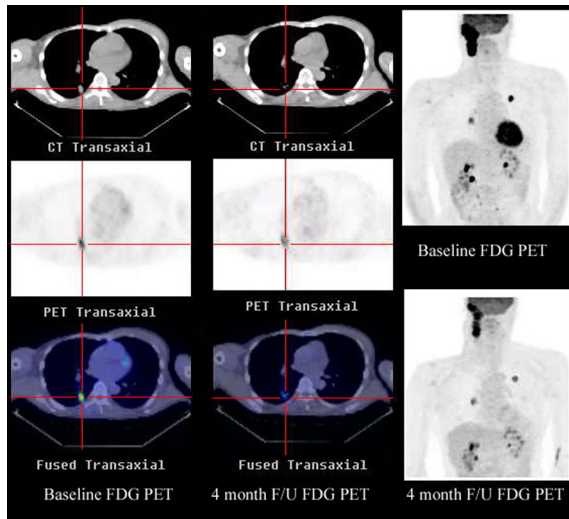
Despite a very favourable response in lung lesions between baseline (left upper) and follow-up (middle upper) CT scans, FDG PET (middle centre) demonstrated ongoing metabolic abnormality consistent with only a partial metabolic response. Fused PET/CT images (left and middle lower) potentially enable partial volume correction. Baseline (right upper) and post-treatment (right lower) maximum intensity projection (MIP) images also revealed minimal metabolic response despite a clinical reduction in the size of cervical lymph nodes.
